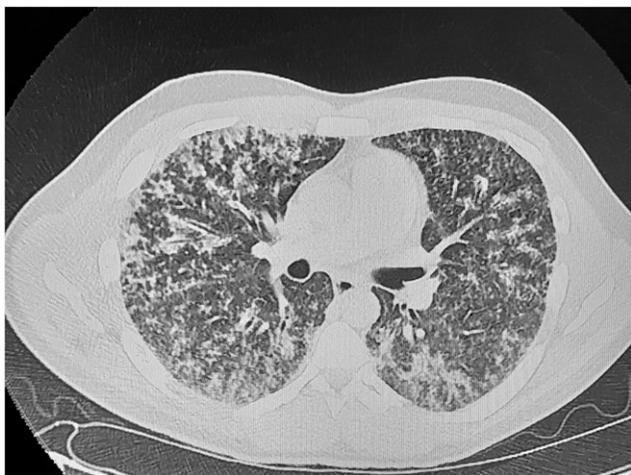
Chest computed tomography showed multiple bilateral centrilobular nodules with a tree-in-bud pattern.
